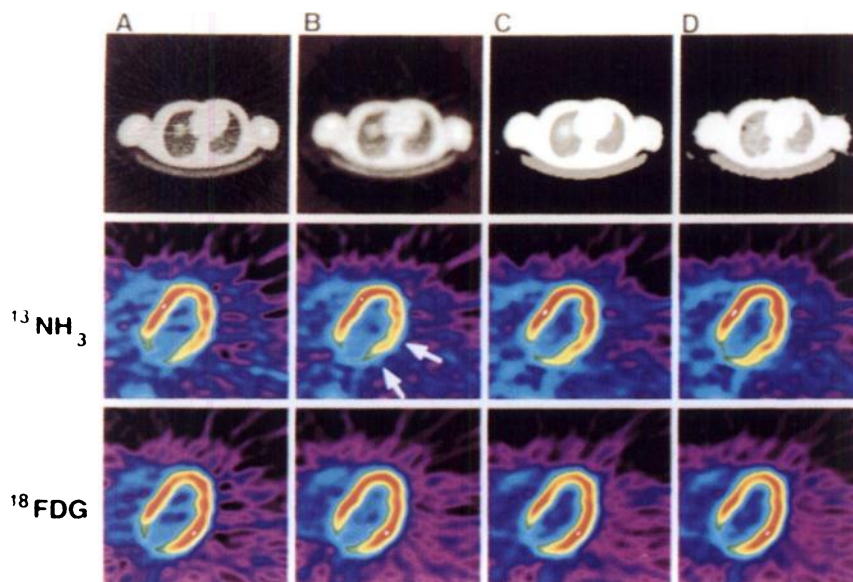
Nitrogen-13-ammonia (middle row) and ^{18}F FDG (bottom row) study in a normal, healthy volunteer. Images were processed using the attenuation data in the top row. The processing used was: (A) long transmission scan with no processing, (B) two-dimensional smoothing of transmission data, (C) segmentation of 20-min transmission data and (D) segmentation of 2-min transmission data.
